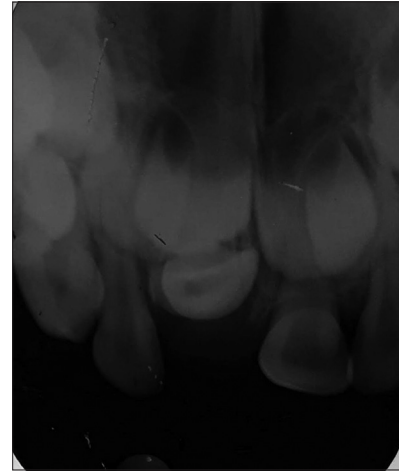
An intraoral periapical radiograph showed impaction of tooth 61.
